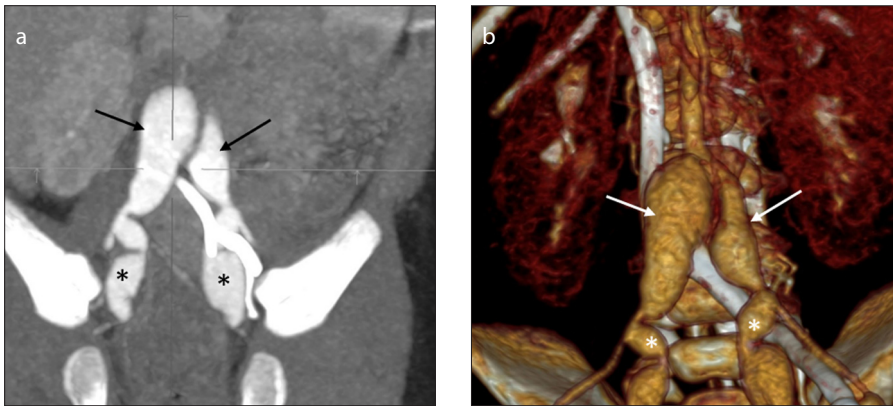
a, b. Bilateral common iliac artery and internal iliac artery aneurysms in a 7-year-old male patient with fever and cervical lymphadenopathy (>2 cm). Coronal MIP CT angiogram (a) shows bilateral common iliac arteries (black arrows) and bilateral internal iliac artery aneurysms (asterisks). Anterior 3D volume-rendered CT image (b) shows bilateral common iliac arteries (white arrows) and bilateral internal iliac artery aneurysms (asterisks).
